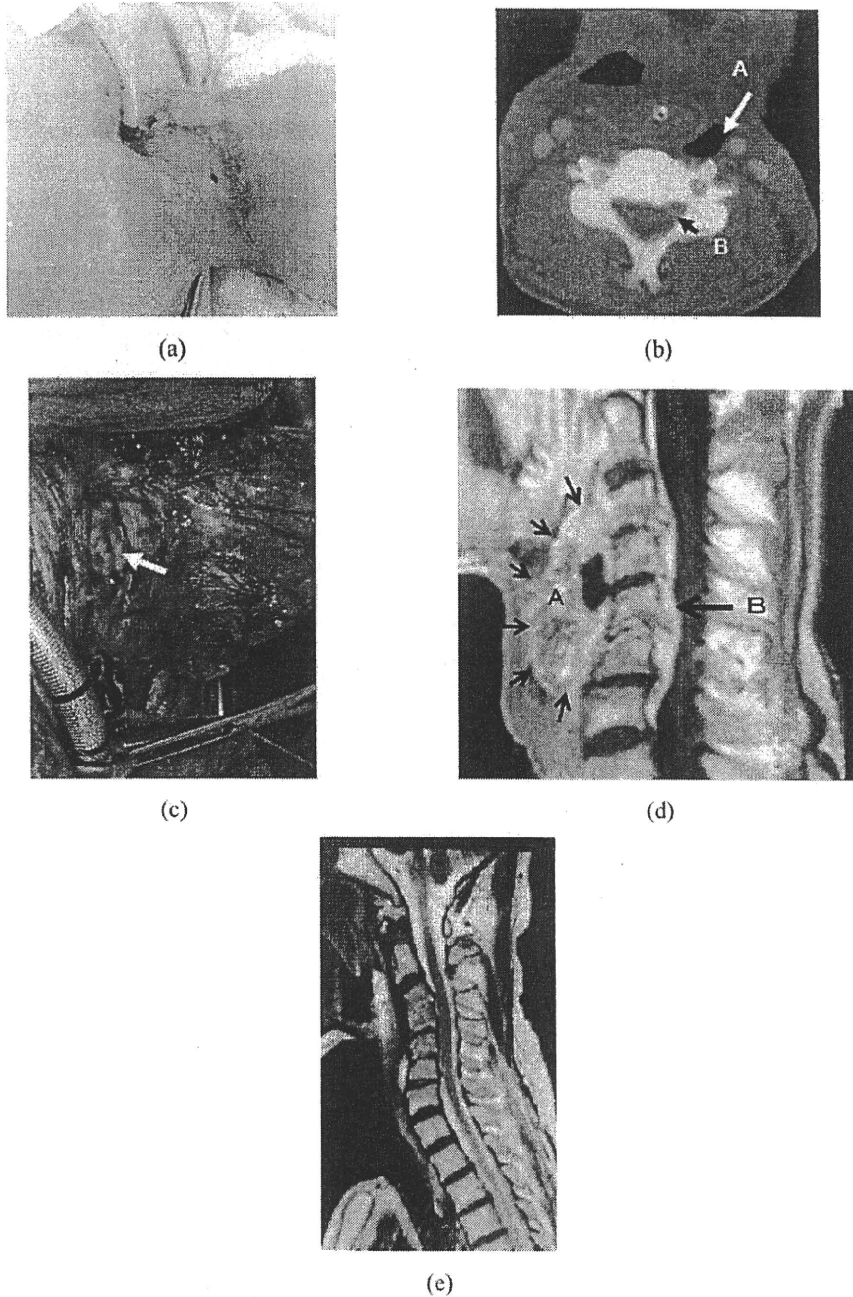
(a) Case 3. A photograph of a patient who had received 68 Gy of radiation for the treatment of hypopharyngeal SCC 14 years before. The chronic cervical fistula is visible. (b) A CT image shows the dead space between the vertebrae and transported jejunum flap (A) and an abscess in the cervical spinal canal (B). (c) An intraoperative photograph shows a fistula leading to the anterior surface of the cervical spine; a contaminated, infected anterior longitudinal ligament is exposed. (arrow). (d) An MRI 7 days after surgery shows the pectoralis major muscle flap placed over the surface of the vertebral bodies (A), as well as inflammatory granulation in the spinal canal (B). (e) An MRI 5 months after surgery confirms that the disappearance of the epidural abscess.
